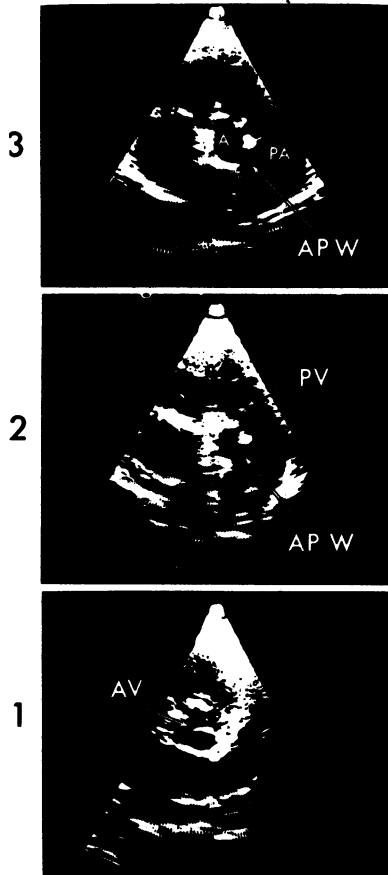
Preoperative two-dimensional echocardiographic findings in case 2. AV, aortic valve; PV, pulmonary valve; AP-W, aorticopulmonary window.
